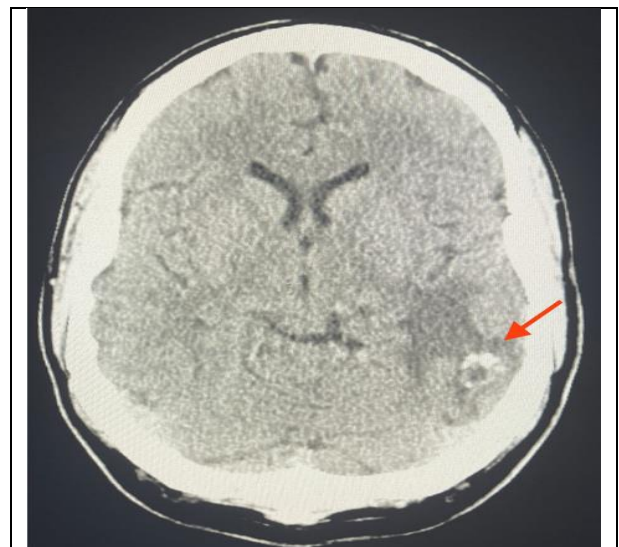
Non-contrast CT conducted during admission revealing a left temporal lobe AVM (red arrow), with no evidence of acute infarctions, intracranial bleeding, or tumor.
